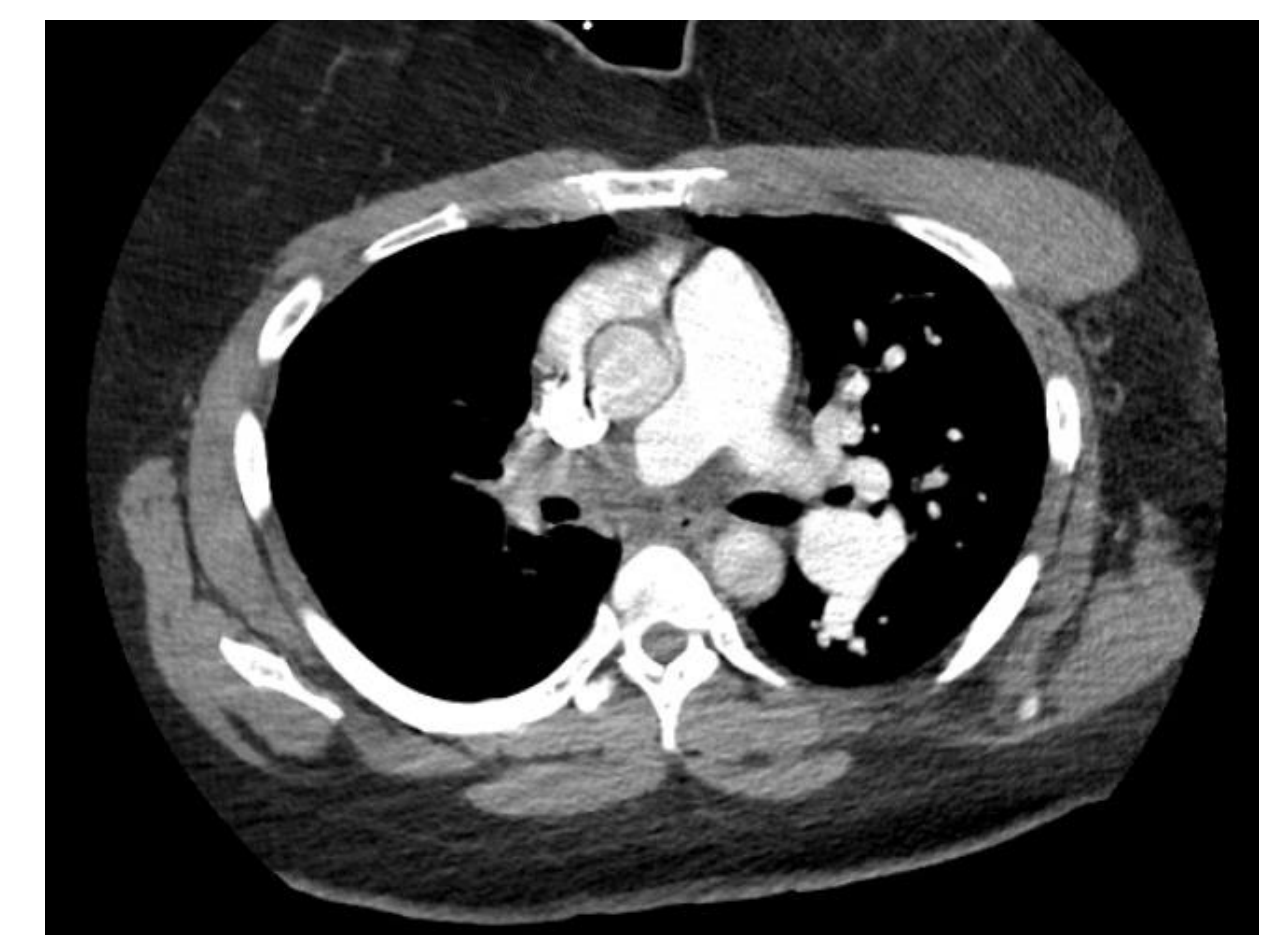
CT scan showing complete obstruction in the right pulmonary artery going to the right lung.
